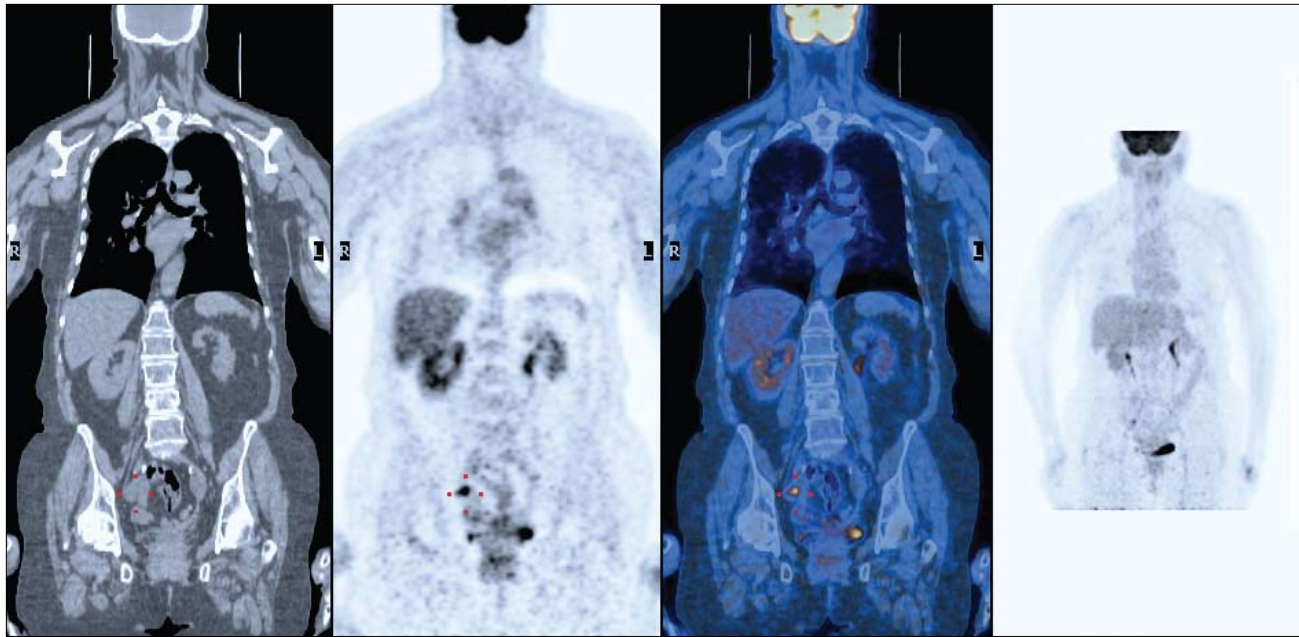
Axial and coronal CT, PET, and fusion PET/CT images, as well as coronal maximum-intensity profile images, demonstrate a right adnexal cystic and solid mass on CT, which shows an increased focal activity of fluorodeoxyglucose in the solid component anteriorly.
